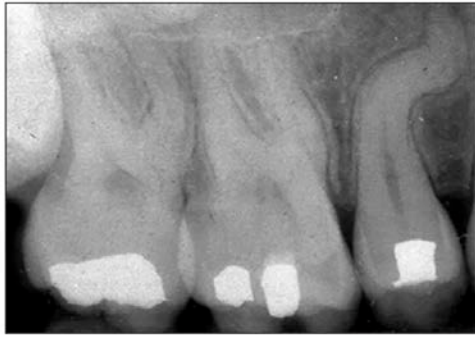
Periapical radiograph of root dilaceration of #4.
